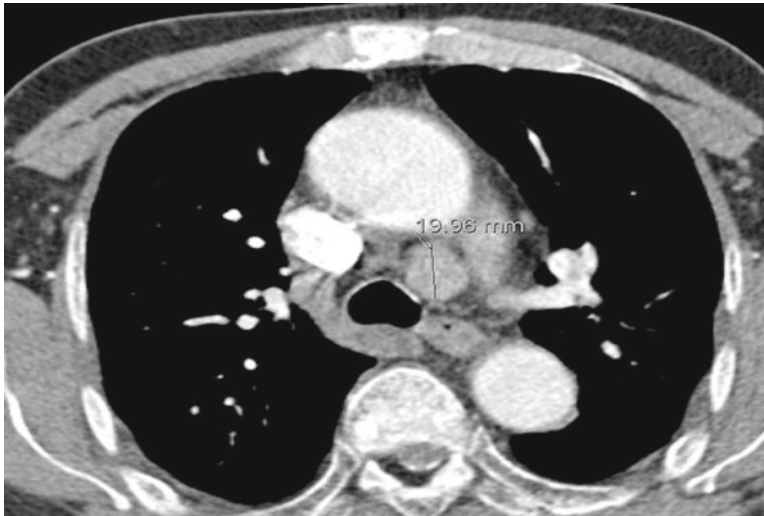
CT scan of atypical localization of parathyroid glands (between trachea and vena cava)
